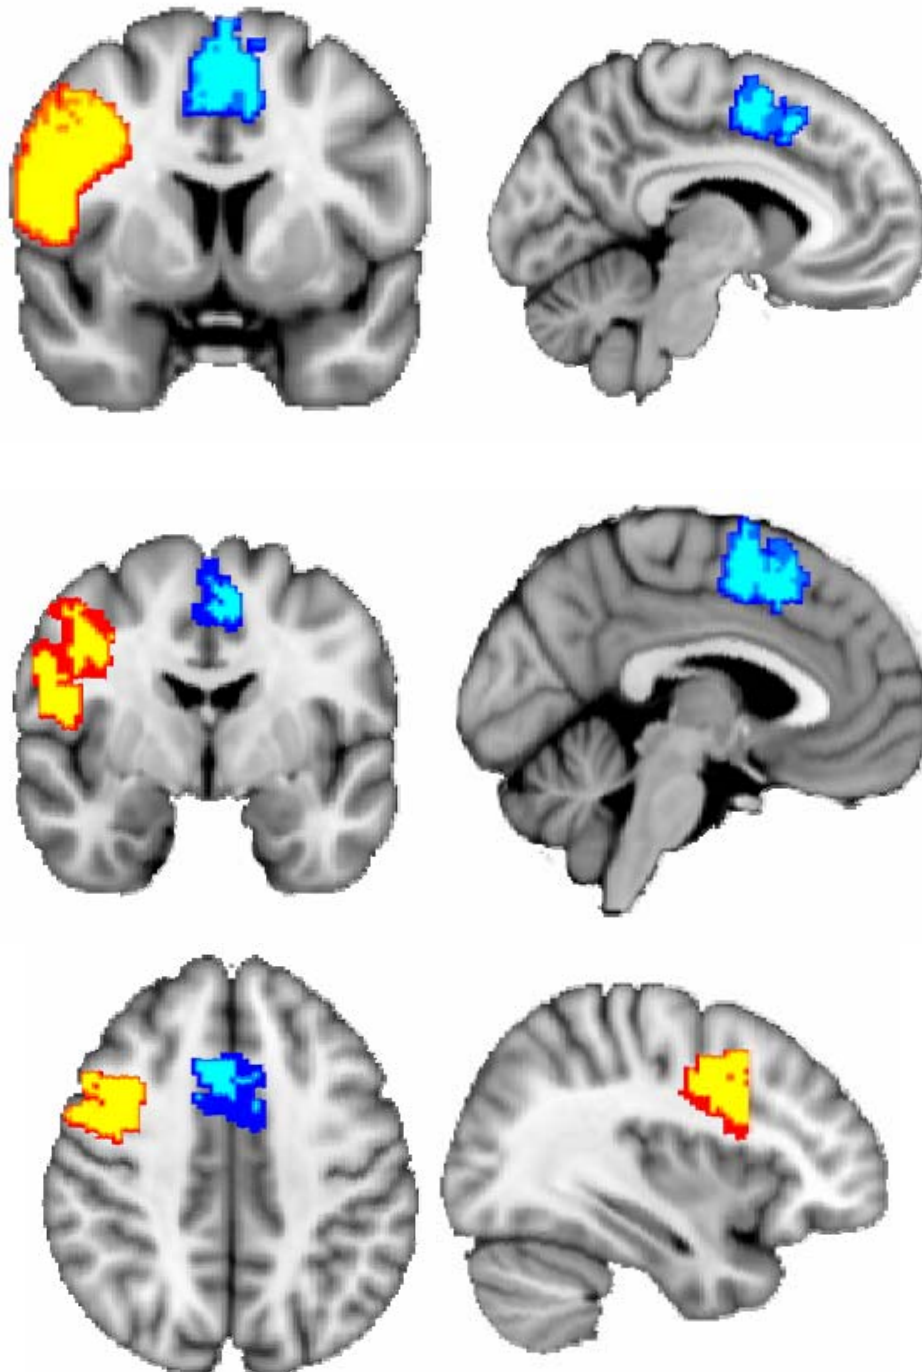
Mask of left and right pre-SMA (blue) derived from a study investigating connectivity profiles of dorsal medial PFC regions by (Johansen-Berg et al., 2004) and kindly provided by Johansen-Berg and colleagues. Mask of right PMv (orange) derived from a study by (Tomassini et al., 2007) and kindly provided by Johansen-Berg and colleagues. Masks are projected onto the T1-weighted MNI-152 brain template. These masks were used as seed masks in the Probabilistic Diffusion Tractography, described in Chapter 2.2.
